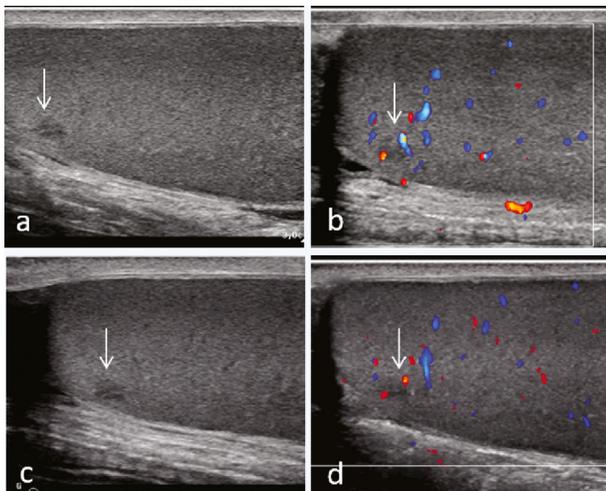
Testicular incidentaloma ultrasound images (*arrows*) reveal a lesion 3.5 mm in diameter. (a) longitudinal projection. (b) Transverse projection on color Doppler imaging. (c,d) Analogous images on a control examination after 8 wk; the monitored area has not changed.
